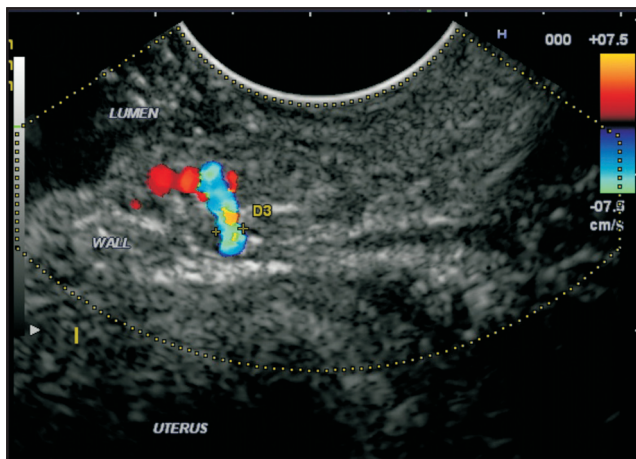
Linear endoscopic ultrasound showed a submucosal vascular lesion in the anterior wall of rectum supplied by an inflowing artery
